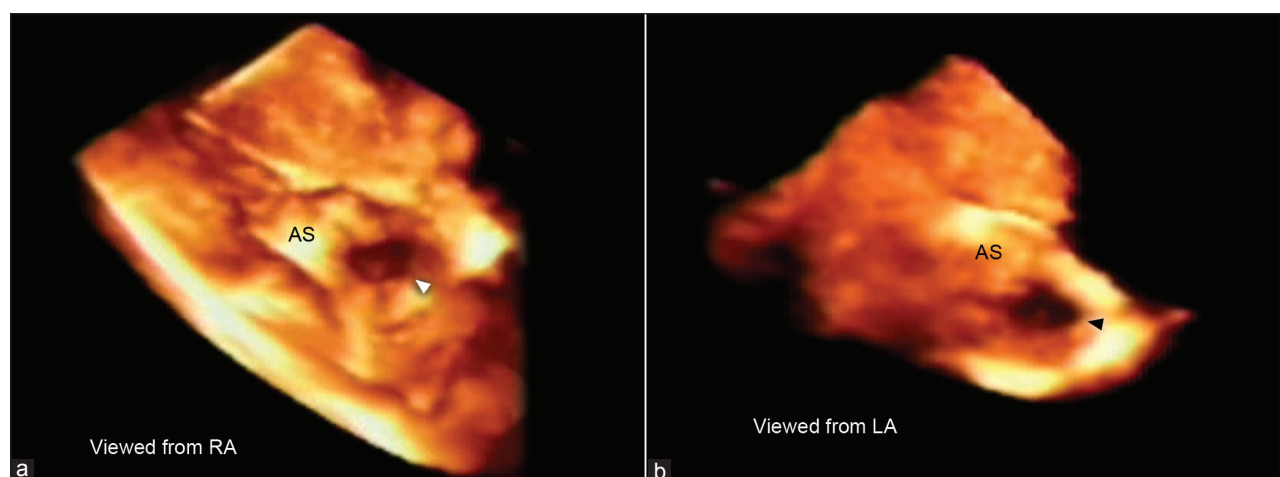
(a and b) Live/real time three-dimensional transthoracic echocardiographic (3D TTE) assessment of atrial septal defect (ASD). Arrowhead points to a large secundum ASD visualized from both right atrial (RA) (a) and left atrial (LA) (b) aspects. Note the large rim of tissue surrounding the defect (AS: Atrial septum). Reproduced with permission from Mehmood F, Vengala S, Nanda NC, et al. Usefulness of live three-dimensional transthoracic echocardiography in the characterization of ASD in adults. *Echocardiography J* 2004;21:707-13
